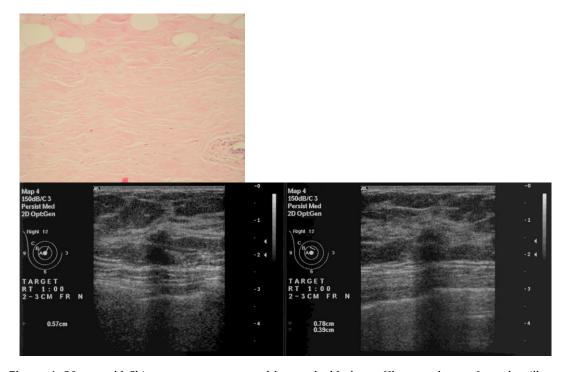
30-year-old Chinese woman, presented by a palpable lump. Ultrasound scan: Irregular, ill-defined, hypoechoic nodule measuring 12 mm; parallel to the skin, decreased sound transmission. Hystopathology: Biopsy displays acellular stromal fibrosis with few fat cells on the top.
